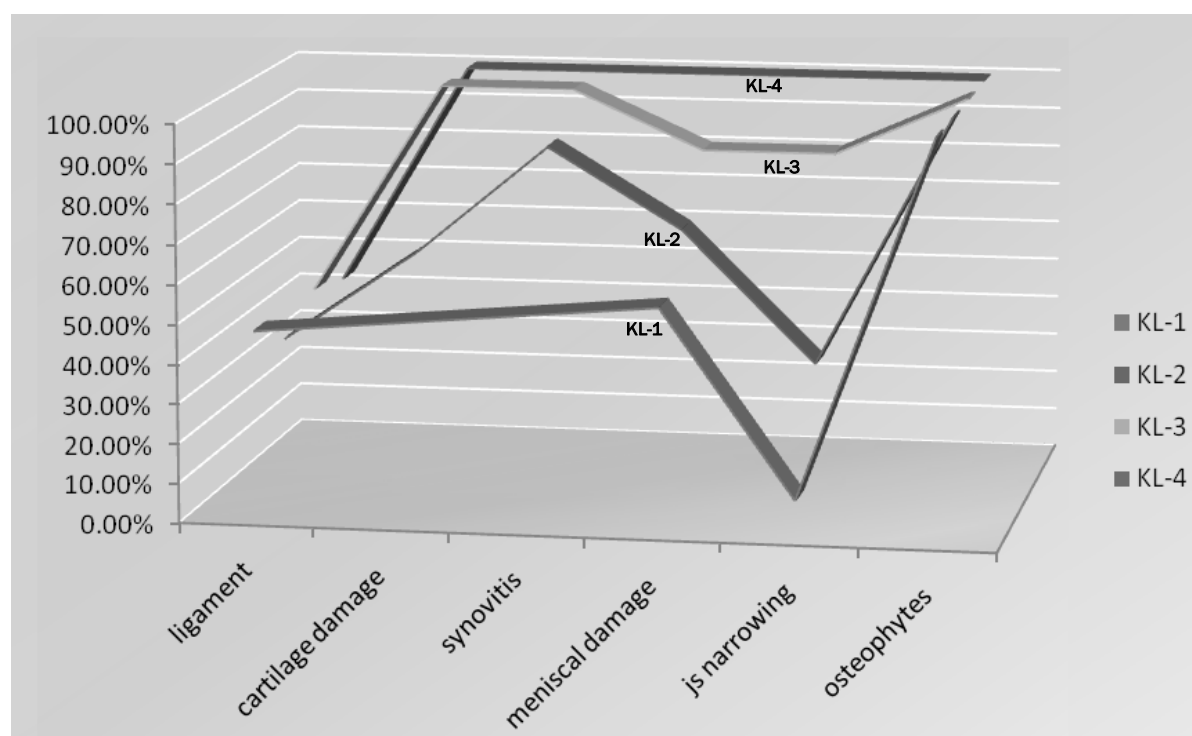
Stacked line graph depicting the frequency of MRI lesions in relation with Kellgren-Lawrence grade
